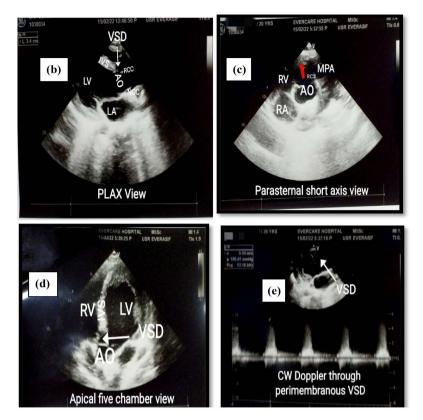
Images (a)-(e) represent preoperative transthoracic echocardiographic. (a) and (b) are parasternal long-axis (PLAX) view; (c) is para sternal short axis view, (d) is Apical five-chamber view; and (e) is continuous-wave Doppler evaluation through VSD. White arrows in the images identify the peri membranous ventricular septal defect (VSD), yellow marked areas in image 'A' demonstrate the measurement of the aortic root, and red arrow in the image 'C' indicating RCS prolapse to right ventricular out-flow. AO (Aorta), VSD (ventricular Septal Defect), RA (Right atrium), LA (Left atrium), LV (left ventricle), MPA (Major Pulmonary artery), RCC (Right coronary Cusp), RCS (Right Coronary Sinus), NCC (Non coronary Cusp).
